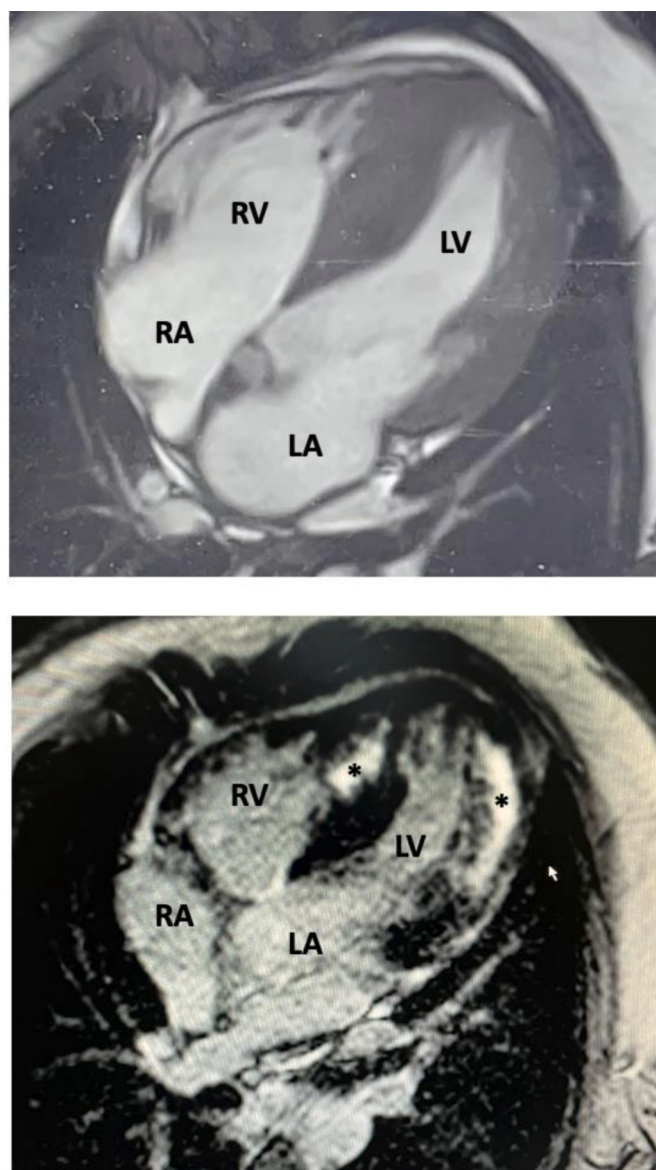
Representative cardiac magnetic resonance images in a patient with *TRIM63*-related HCM. Top panel: SSFP cine image, demonstrating marked concentric left ventricular hypertrophy with preserved global systolic function. Enlargement of both atria, particularly the left atrium, is also noted. Bottom panel: Four-chamber LGE image from a different patient in an advanced disease stage, showing extensive, confluent areas of transmural fibrosis involving the interventricular septum and anterior wall (indicated by asterisks). These images exemplify the progressive myocardial remodeling typical of *TRIM63*-related cardiomyopathy, from early hypertrophy to massive fibrotic evolution. Abbreviations: HCM: Hypertrophic Cardiomyopathy; LV: left ventricle; RV: right ventricle; LA: left atrium; RA: right atrium; LGE: late gadolinium enhancement; CMR: cardiac magnetic resonance; SSFP: steady-state free precession.
